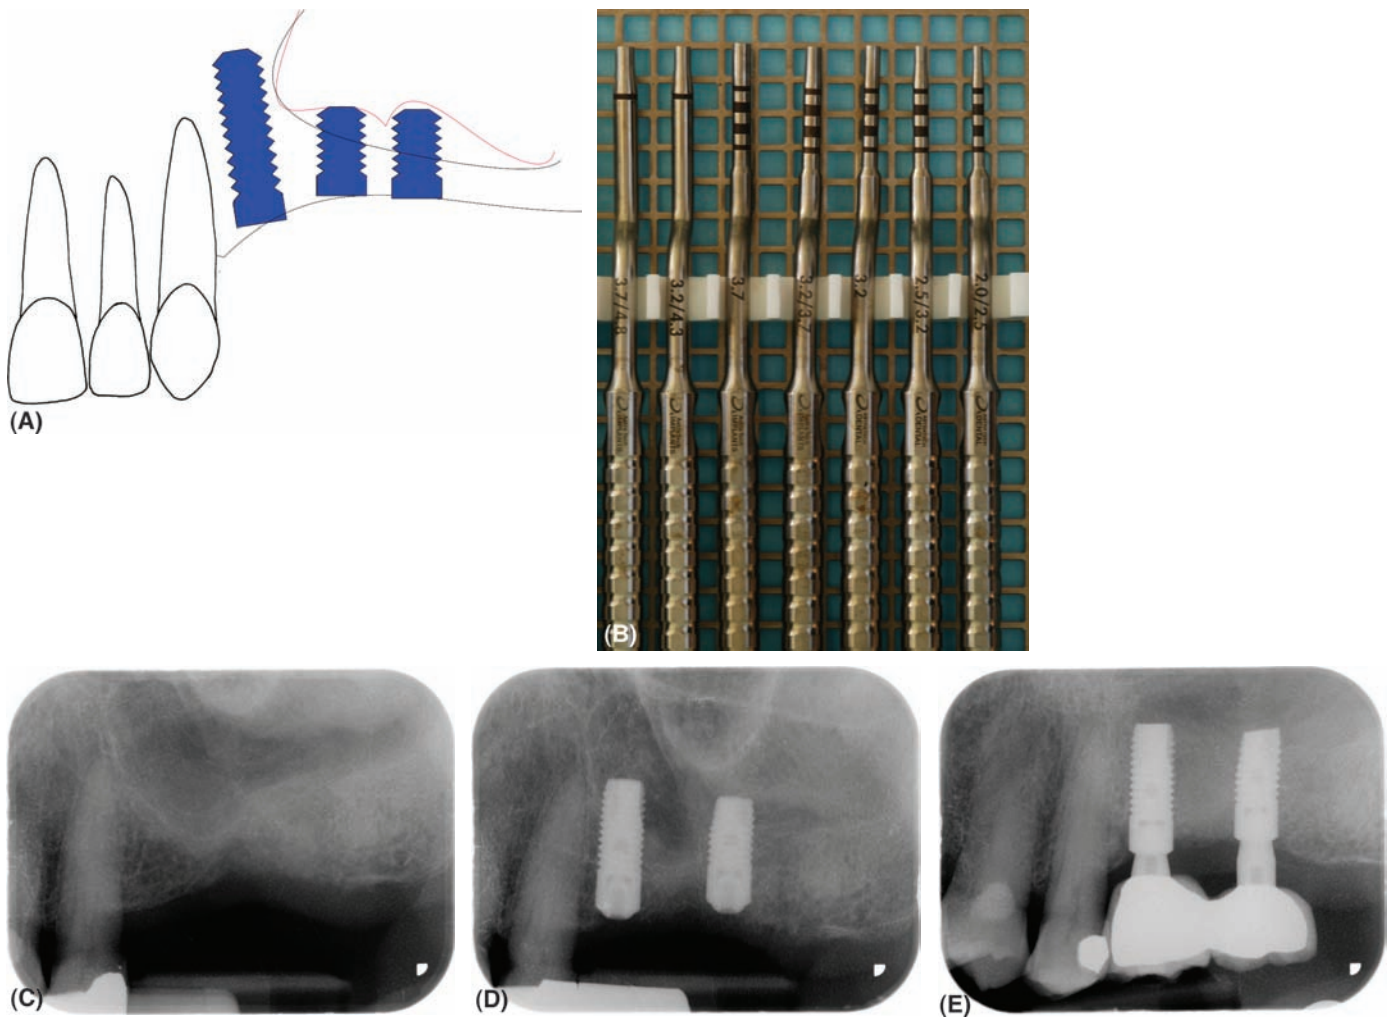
(A) The floor of the sinus may be elevated at each osteotomy site using Summers' technique. By pushing a plug of bone apically with osteotomes, the floor may be infrafractured leaving the sinus membrane intact. (B) A set of Astra Tech osteotomes for transalveolar sinus lift procedures. The handles are cranked to improve access and the tips are concave to aid cutting and compression of the bone. (C) Preoperative radiograph of the left maxilla showing less than 5-mm bone height. (D) Postoperative radiograph one week after a transalveolar sinus lift. (E) Radiograph after restoration showing bone consolidation around the implants and increase in bone height beneath the sinus floor.
